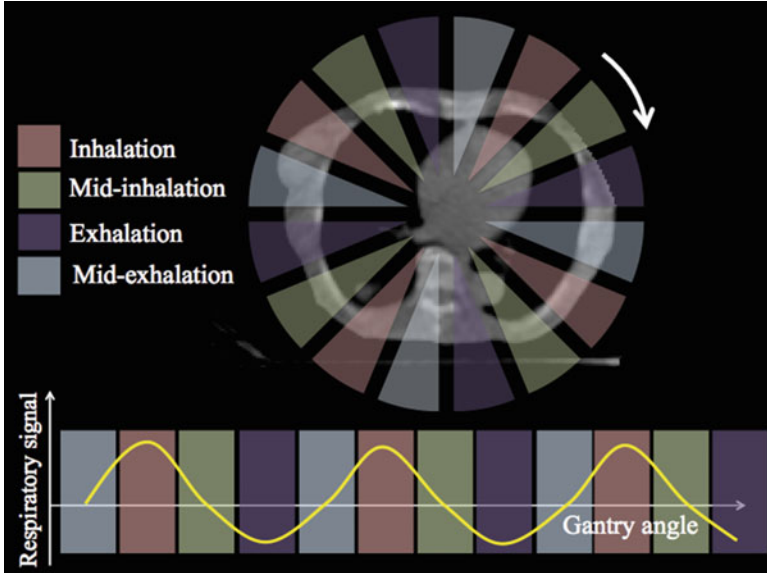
Principle of 4D CBCT reconstruction using image-guided system mounted on LINAC. The projection images are classified into the phase bins defined with the respiratory signal. Thus, 4D CBCT set is generated by reconstructing with each subset of projections
